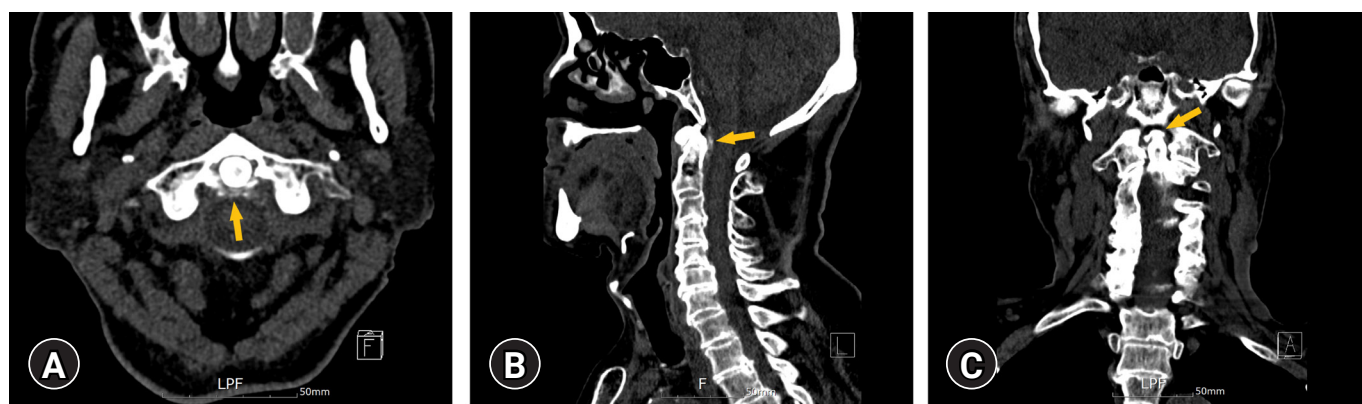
(A) Axial, (B) sagittal, and (C) coronal computed tomography scans at the C1 and C2 level demonstrate crown-shaped calcium deposits (arrows) at the posterolateral side of the odontoid process.
